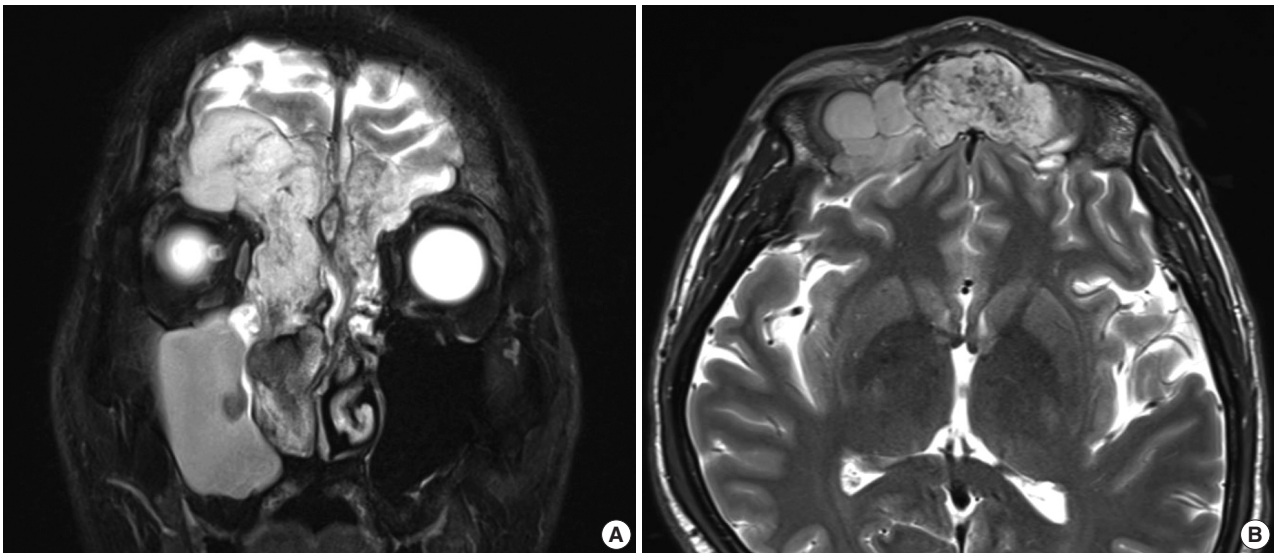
Coronal (A) and transverse (B) magnetic resonance imaging shows a mass in the right nasal cavity and bilateral frontal sinus.
